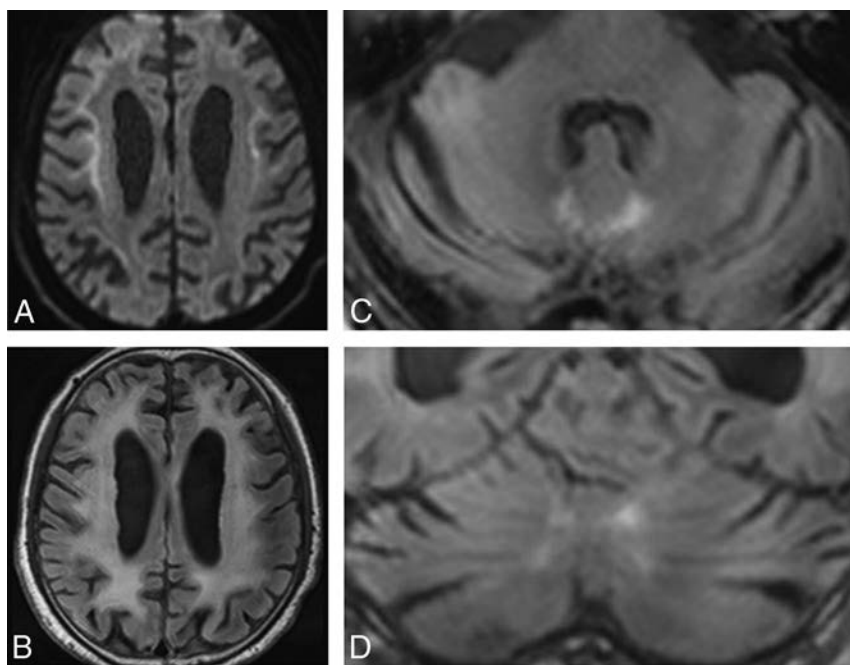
Patient 4. DWI (A) shows high-intensity signal along the corticomedullary junction. A FLAIR axial image (B) shows diffuse high intensity in the bilateral cerebral hemispheres. FLAIR axial (C) and coronal (D) images show atrophy of the cerebellum and high-intensity signal in the medial part of the cerebellar hemisphere right beside the vermis (the paravermal area).
